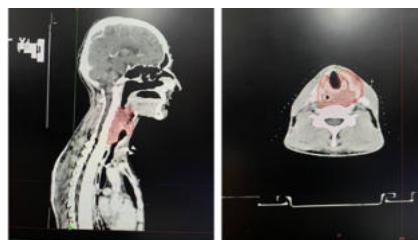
CT neck (left- sagittal view, right- axial view)
